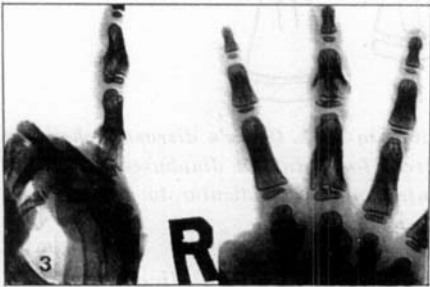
Radiographs of the right hand the child who's left hand is seen in Figure 2. Age three years.
